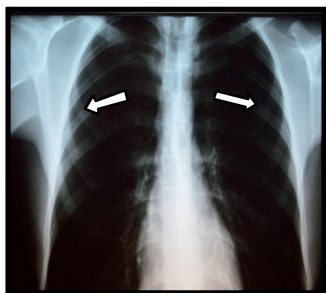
Frontal chest radiography showing bilateral gaseous pleural effusion
